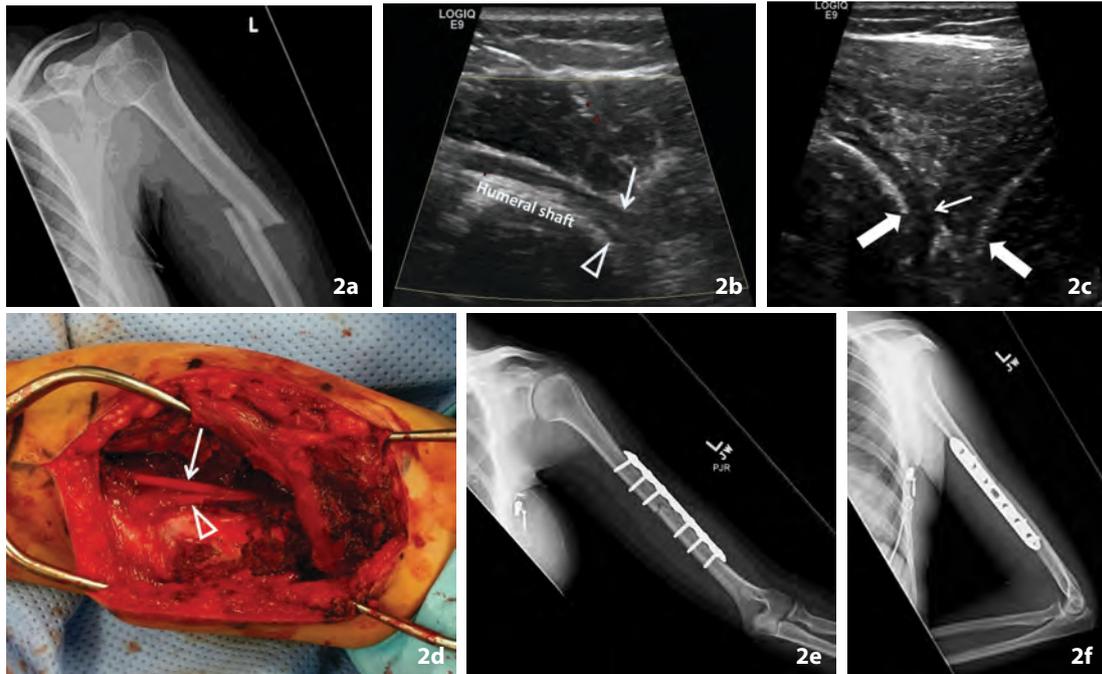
Transverse humeral shaft fracture with associated radial nerve entrapment and partial laceration in a 33-year-old female status post bicycle accident (Patient 8). (A) AP radiograph of the left humerus shows completely displaced mildly overriding humeral shaft fracture. (B) Long axis power Doppler US image at the level of the left humeral shaft fracture shows radial nerve entrapment at the fracture site (arrow) with partial laceration (arrowhead). (C) Long axis grayscale US image shows radial nerve entrapment (arrow) at the humeral shaft fracture site (block arrows). (D) Intraoperative photograph of the posterior aspect of the right arm confirmed radial nerve entrapment (arrow) and partial laceration (arrowhead) at the humeral shaft fracture site which correlates with the US findings. (E) AP and (F) lateral postoperative radiographs of the left humerus obtained two weeks later show a laterally applied low contact dynamic compression plate with 6 cortical screws transfixing the left humeral shaft fracture in anatomic alignment and without hardware complication. The patient achieved full radial nerve recovery at final follow up.
